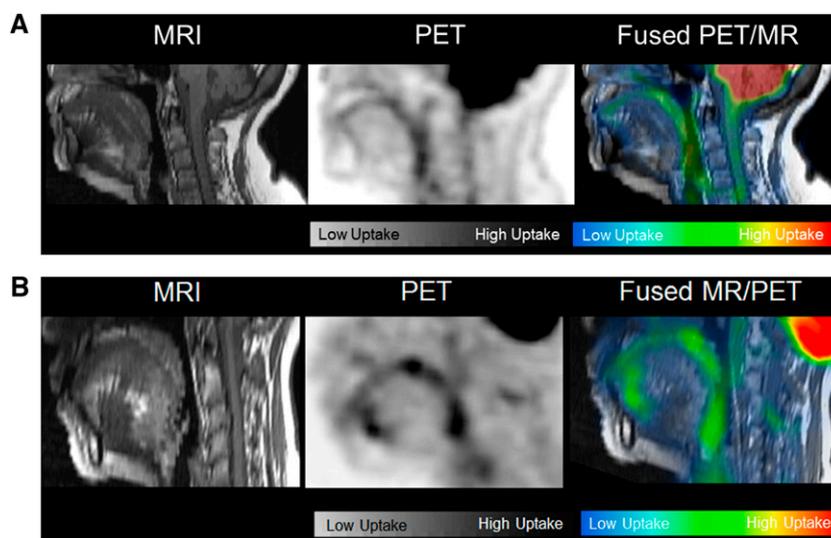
(A) Representative magnetic resonance imaging (MRI), positron emission tomography (PET), and fused PET-MRI of the upper airway in a patient with sleep apnea. Color bars below the PET and fused MRI-PET image indicate high uptake (black, red) and low/no uptake (white, blue). (B) Representative MRI, PET, and fused PET-MRI of the upper airway in control subject. Color bars below the PET and fused MRI-PET image indicate high uptake (black, red) and low/no uptake (white, blue).
